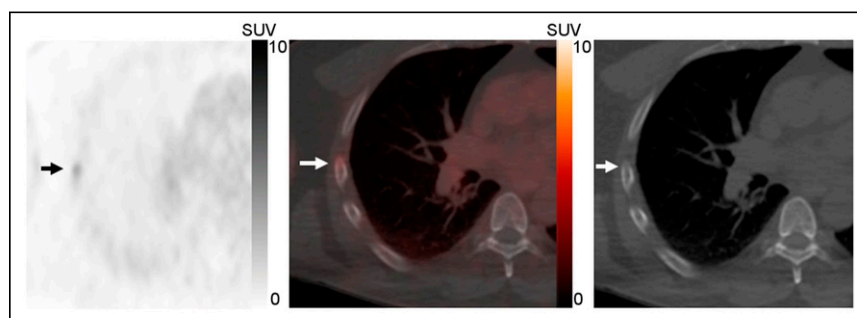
A 63-y-old patient with BCR PCa and PSA of 0.46 ng/mL. Axial ^{18}F -DCFPyL PET (left), ^{18}F -DCFPyL PET/CT (middle), and CT (right) images show a single area of subtle PSMA-avid uptake with SUV_{max} of 2.4 in the right fifth rib and no CT correlate (arrows). This IBL was determined to be benign based on negative 17-mo follow-up bone scintigraphy findings.
